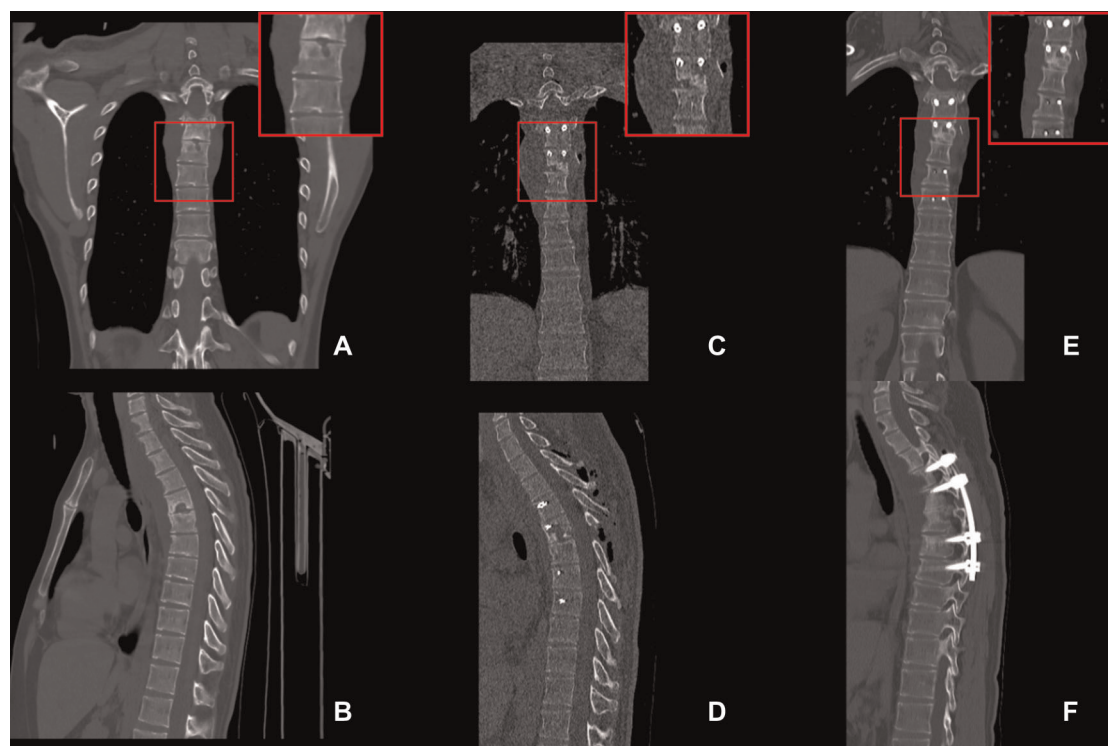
Images for selected typical case. A 32-year-old male patient was diagnosed with thoracic vertebral tuberculosis and underwent posterior spinal tuberculosis debridement, bone grafting, fusion, and internal fixation in our hospital (Figure 2). The patient had no osteoporosis and did not take medication regularly one year after surgery. (A/B) A are the preoperative CT scan of the thoracic spine showed bone destruction in the thoracic spine. (C/D) Postoperative CT scan of the thoracic spine showed that the bone graft exhibited good contact with the upper and lower vertebral bodies. (E/F) Plain CT scan of the thoracic spine at the 1-year follow-up. There is a clear boundary between the bone graft and the autologous bone, and the bone graft is not fused.
